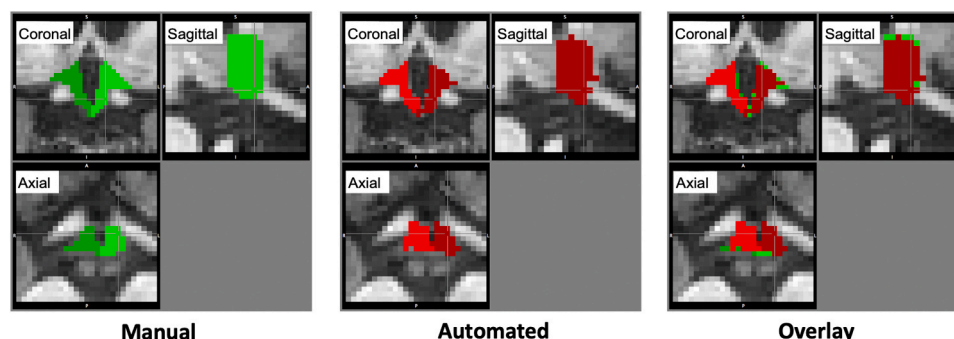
Comparison of the manual and automated delineation of the hypothalamus in a representative LonGenity Brain MRI cohort participant.
